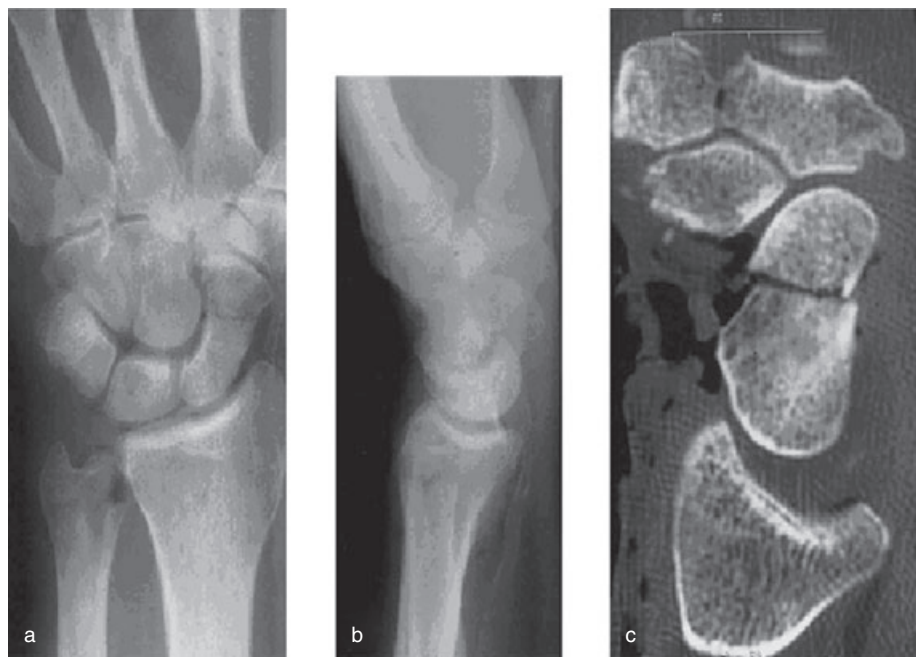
Comparison of x-ray and CT scan demonstrating scaphoid fracture displacement. Images of a scaphoid fracture showing minimal displacement in the plain x-ray PA (a) and lateral (b) views, but a clear view of 1 mm displacement in the sagittal CT scan view (c). (Reprinted from Temple CLF, Ross DC, Bennett JD et al., *Comparison of sagittal computed tomography and plain film radiography in scaphoid fracture model.* *J. Hand Surg.* 2005; 30A: 534–42, with permission from Elsevier).
